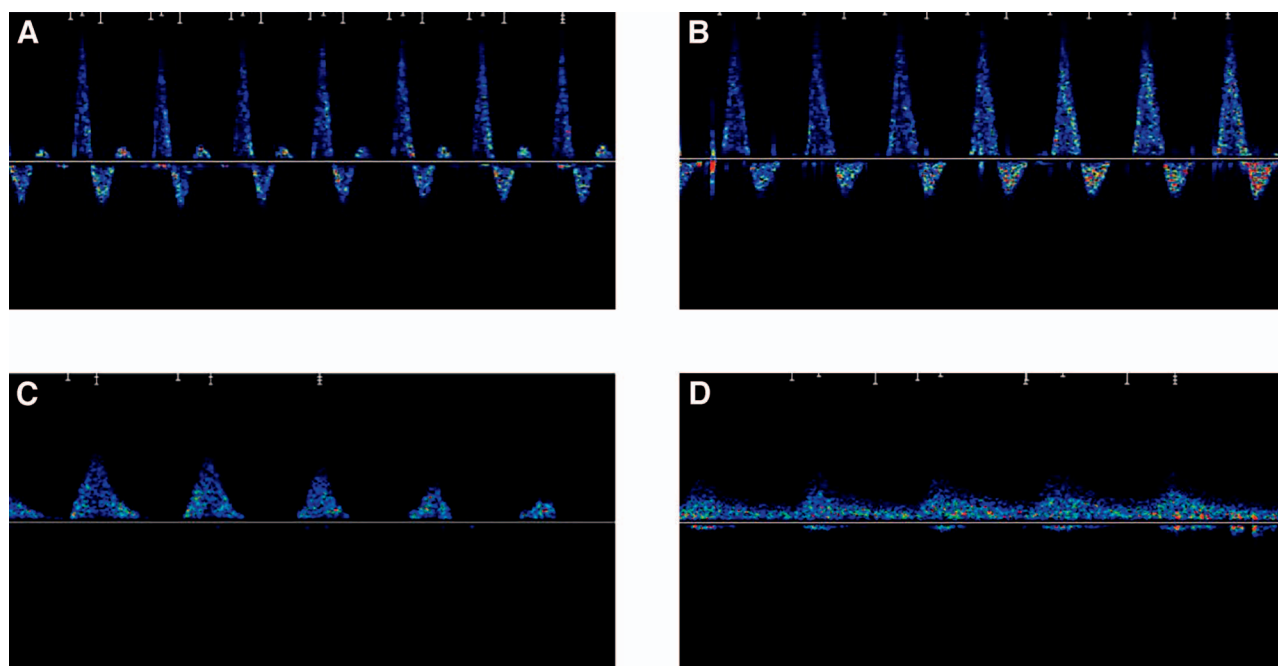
Spectral Doppler waveforms as visualized on the proprietary AR2 software. Waveforms are depicted as triphasic (A), biphasic (B), monophasic (C), and monophasic continuous (D).
